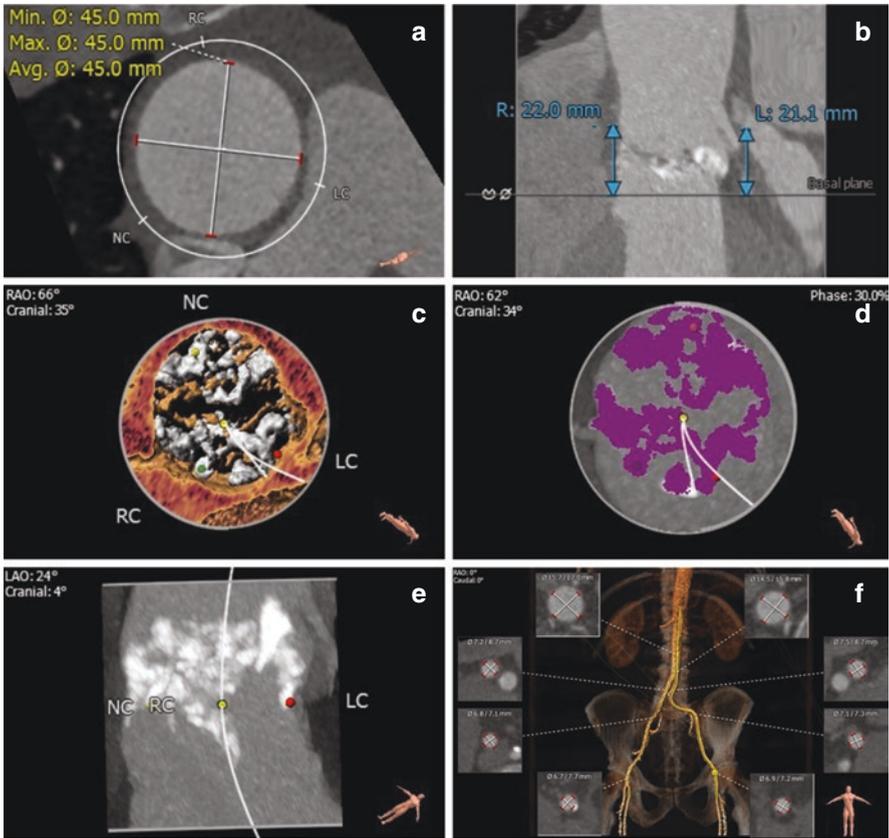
Reconstructed CT images. (a) Maximal diameter of the ascending aorta, (b) the coronary artery height, (c) calcium distribution of the aortic valve, (d, e) the extent of valve calcification, (f) the dimension of the iliofemoral arteries
